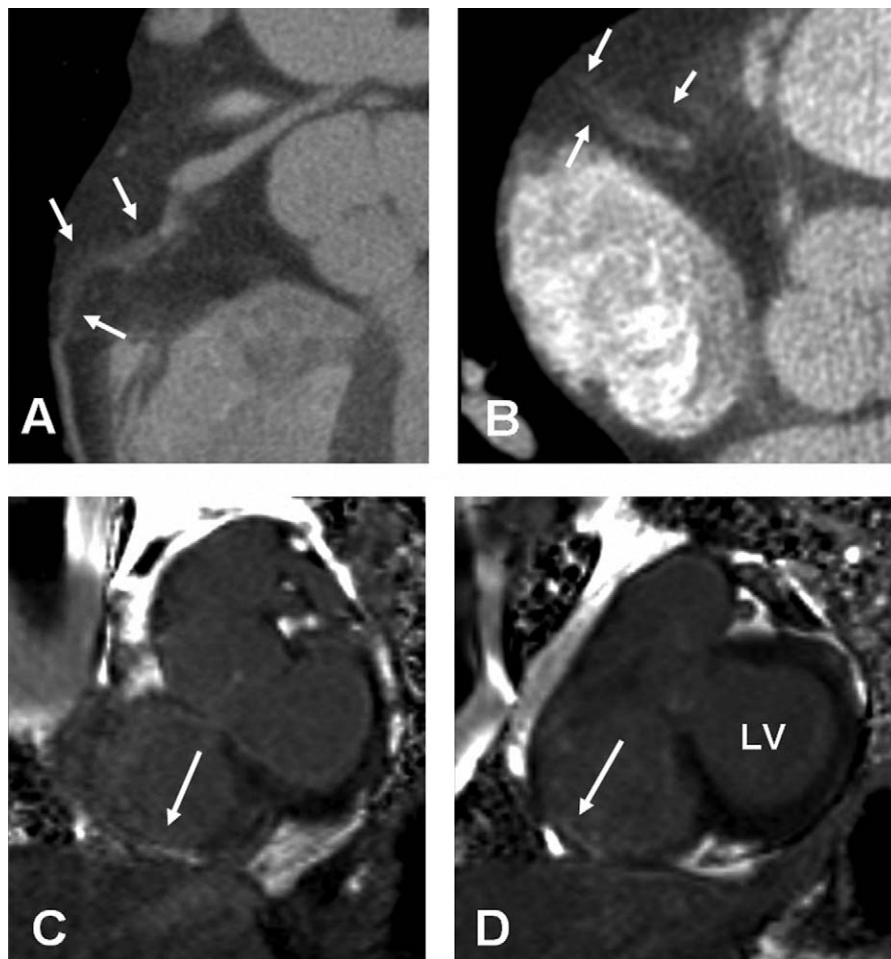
Upper panel depicts curved reconstruction (A) and axial views of the RCA. The thrombosed segment is shown by small arrows. In B, a linear filling defect is seen within the thrombosed segment surrounded by contrast, which may represent clot. Lower panel (C and D) shows short axis images of delayed contrast enhanced MRI (phased sensitive, inversion recovery fast gradient echo). Long arrows point to hyper enhancement of the inferior and inferolateral walls of the right ventricle at the basal level. Cine MR (not shown) demonstrated severe hypokinesis of the RV in the area of abnormal enhancement. LV indicates left ventricle; MRI, magnetic resonance imaging; RV, right ventricle.
